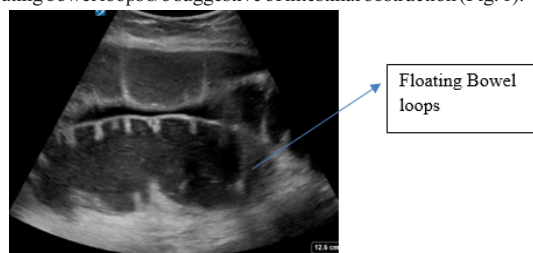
Ultrasound showing dense floating bowel loops suggestive of intestinal obstruction
